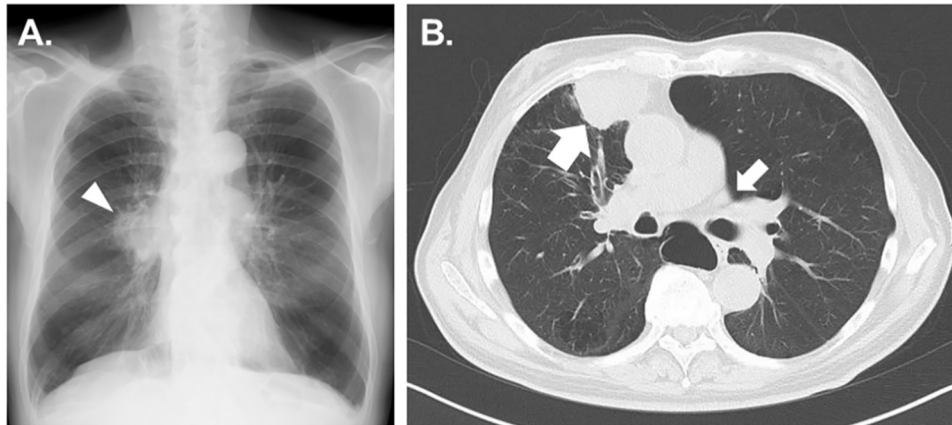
The radiographic findings. A conventional chest radiograph showing a solitary circular opacity (white arrowhead) in the right pulmonary hilar region (A). A chest CT image showing a well-marginated soft-tissue nodule in the right upper lobe anterior segment (wide arrow) with distinct lymphadenopathy (narrow arrow) (B).
